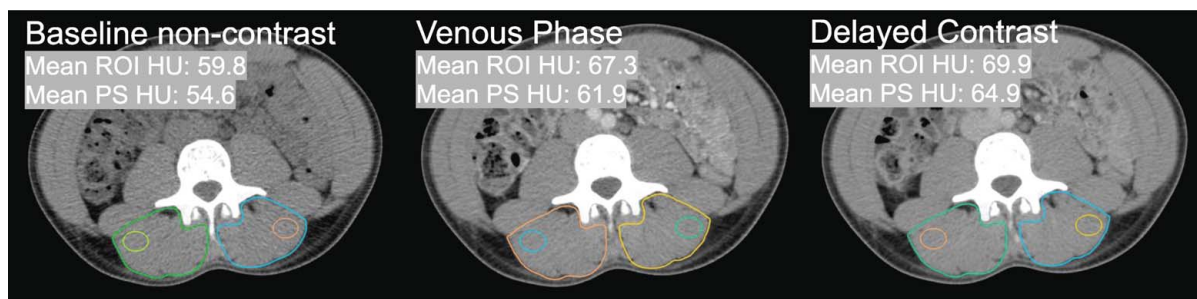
Example ROI and PS HU for NC, VC, and delayed phase contrast CT scans.
